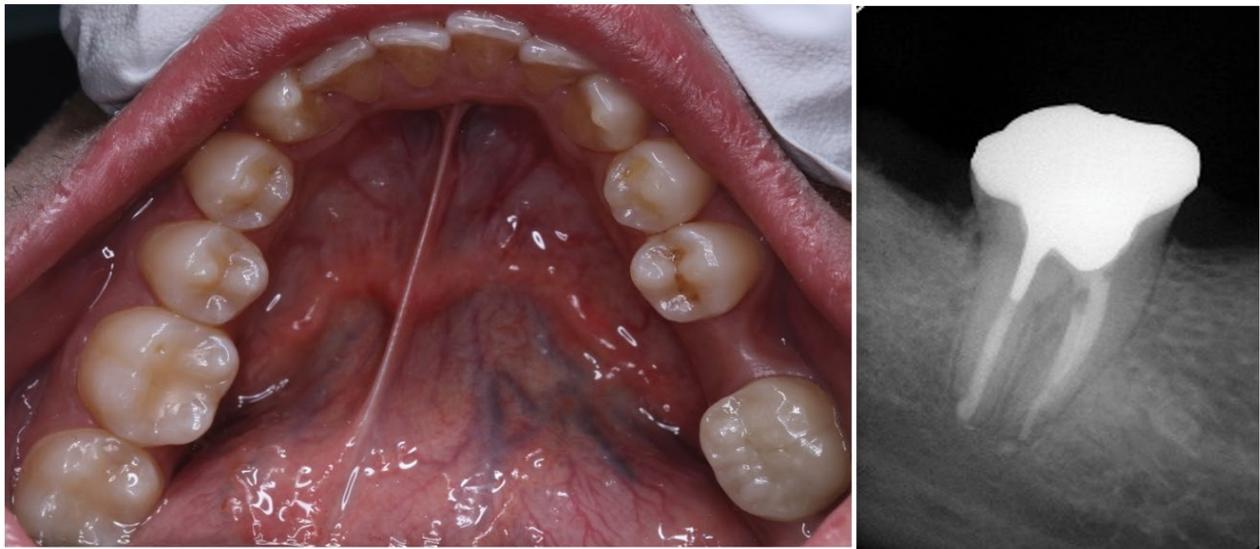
Pre-operative clinical photograph and periapical radiograph, intraoral photo with a mandibular occlusal view showing the symptomatic tooth (#47). periapical radiograph of tooth #47, showing a widening in PDL space, periapical lesion, and extruded gutta-percha beyond the radiographical root apex
